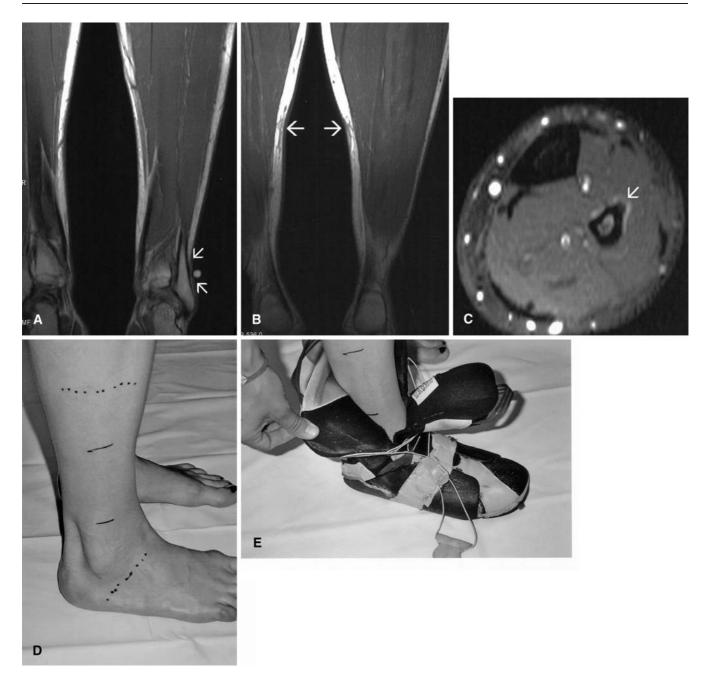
A 25-year-old professional female snowboarder with a 12-week history of a focal pain in the lateral malleolar region. She had a minimum of 8-h training sessions daily for a continuous period of 3 months. The other 17-year-old female professional snowboarder had the same clinical history, training scheme, and MR imaging findings. A Coronal T1-weighting (TR: 536, TE: 13) with a vitamin capsule demarcating the maximal region of pain and the location of the soft-tissue mass-like region (*arrows*). B More posterior, coronal T1-weighting shows altered subcutaneous signal intensity (*arrows*) corresponding to the medial aspect of the soft
